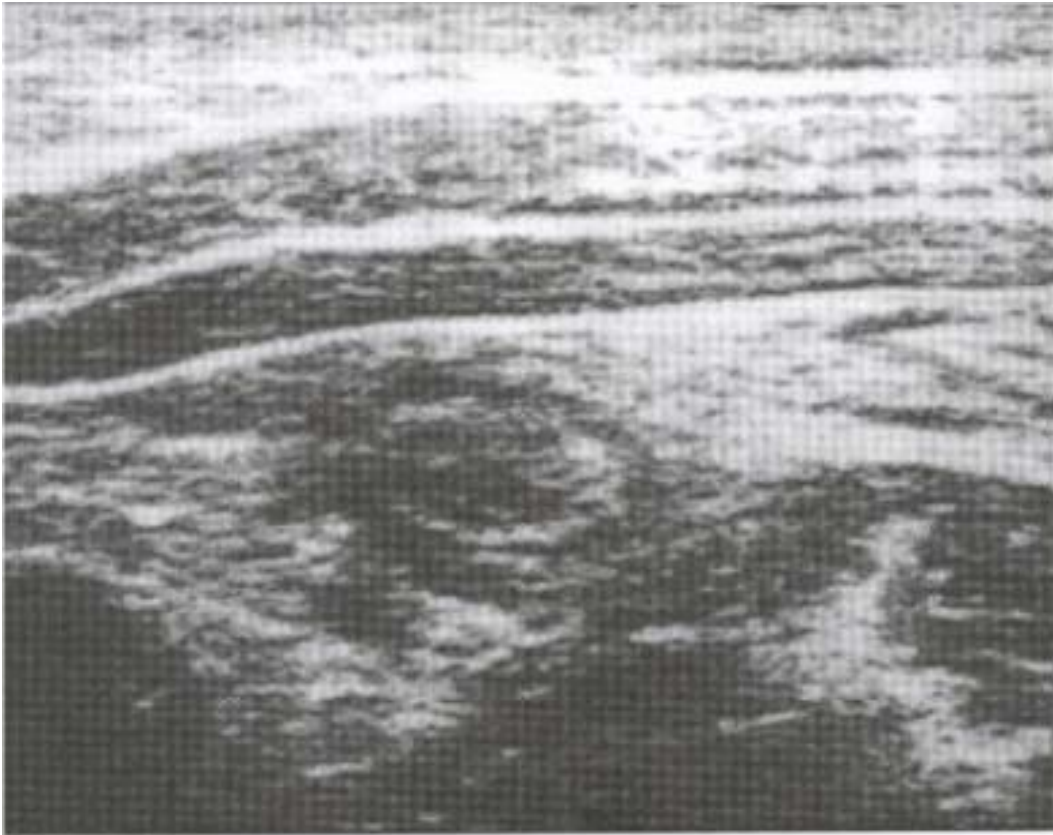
Matching Alvarado score with ultrasound and Doppler activity
